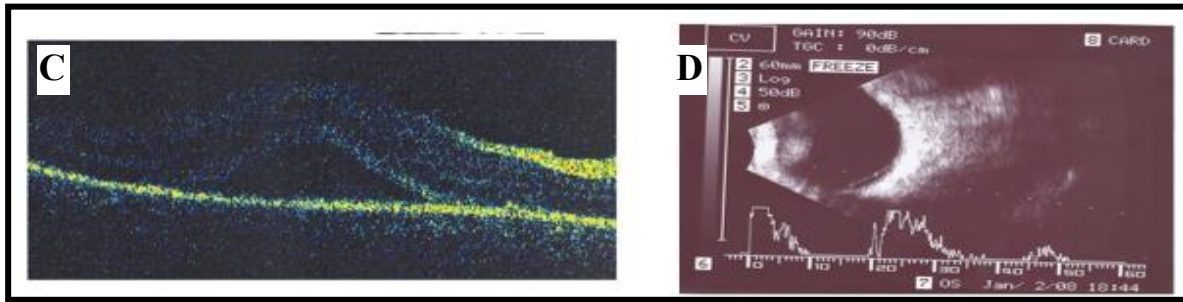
Initial examination of the left eye in case one (A) Color fundus images, (B) Fluorescence angiography, (C) O.C.T, and (D) ultrasonography.
